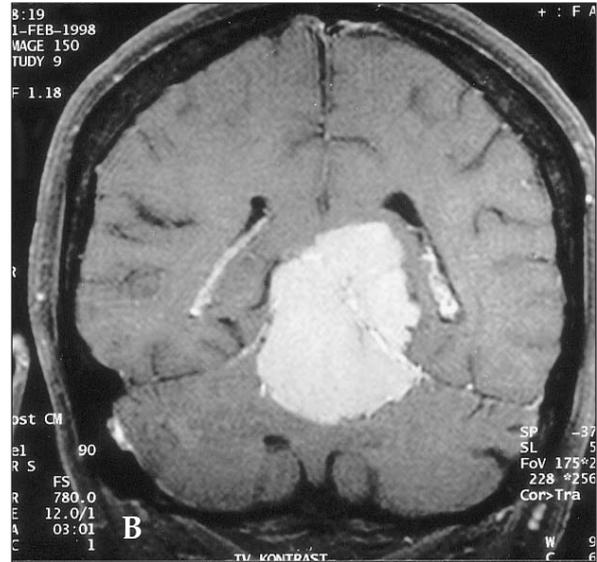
1B, 1C: Case 1: A huge solid mass, prominently enhanced, is seen in the pineal region on axial, coronal and sagittal planes in T1-weighted images with gadolinium.
